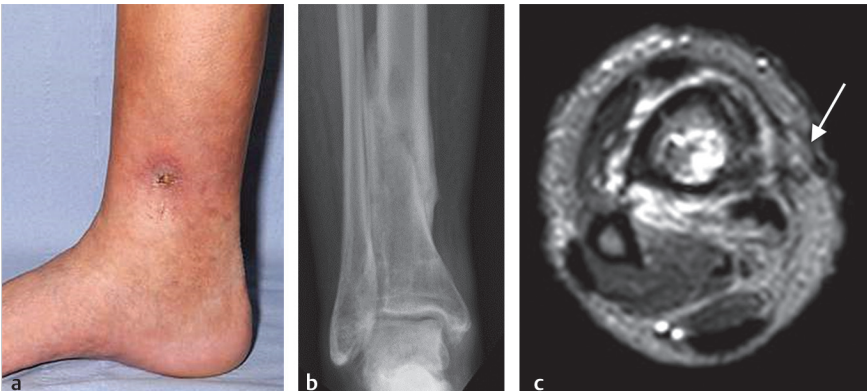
(a–j) This 51-year-old woman suffered an open fracture of the tibia that was treated with an intramedullary nail. The fracture healed, but she remained with a draining sinus (a) after nail removal and reaming. The X-ray (b) and magnetic resonance imaging (MRI) (c) scan confirmed the areas of bone loss and cortico-medullary osteomyelitis, with a medial sinus (white arrow).
